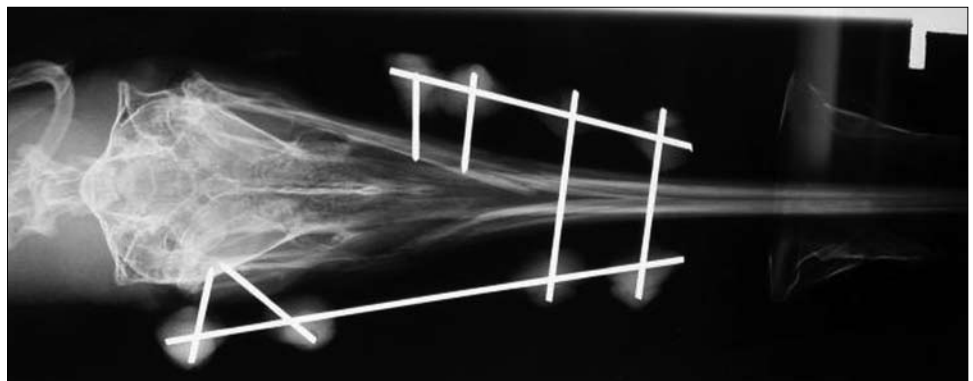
Lateral radiograph of a North Island brown kiwi with multiple mandibular fractures.
